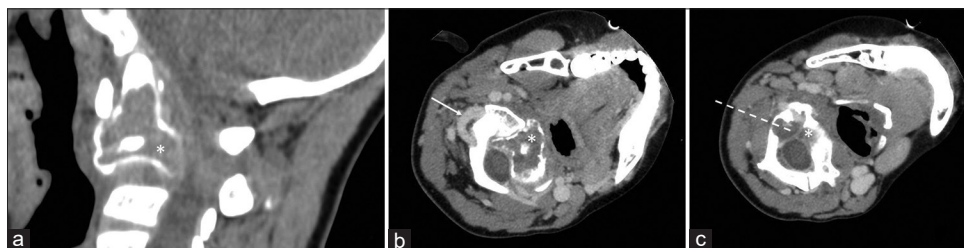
(a) A sagittal view of a computed tomography (CT) scan showing a lytic and expanding lesion within the body of the C2 vertebra. Noticeable thinning of the cortical bone is clearly visible. (b) An axial view of a contrast-enhanced CT scan, highlighting the course of the vertebral artery (arrow). Additionally, the scan shows the lytic lesion within the C2 vertebra (asterisk). (c) The planned path of the needle for biopsy is delineated by a dotted line. This shows the proposed trajectory for biopsy, carefully planned to avoid damage to the vertebral artery and other crucial structures
